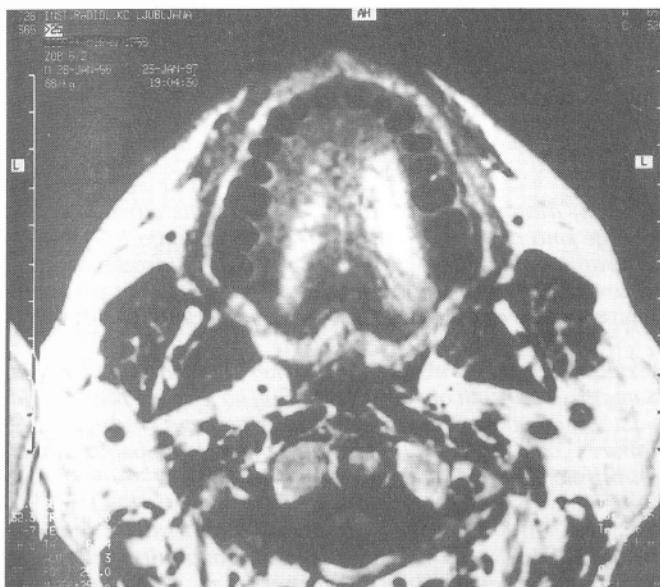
MR image of a 3 mm thick slice through the maxilla, made after the therapy. The image is of the same slice as in Figure 2. A decrease in inflammation of periodontal tissues and a decrease of SI in those tissues can be observed.
